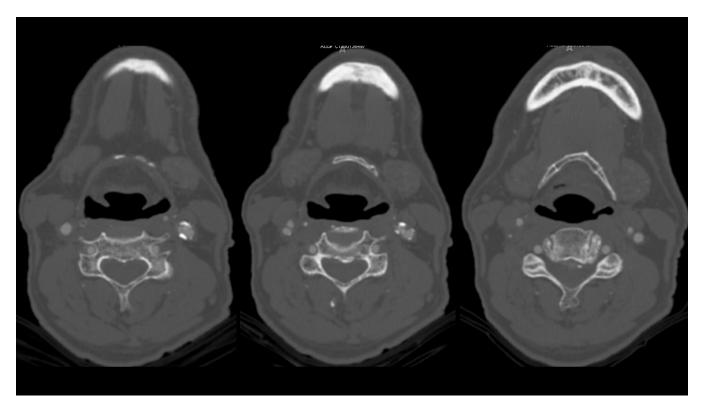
Cervical CTA with progressive axial views revealing right carotid artery stenosis 90-95%
